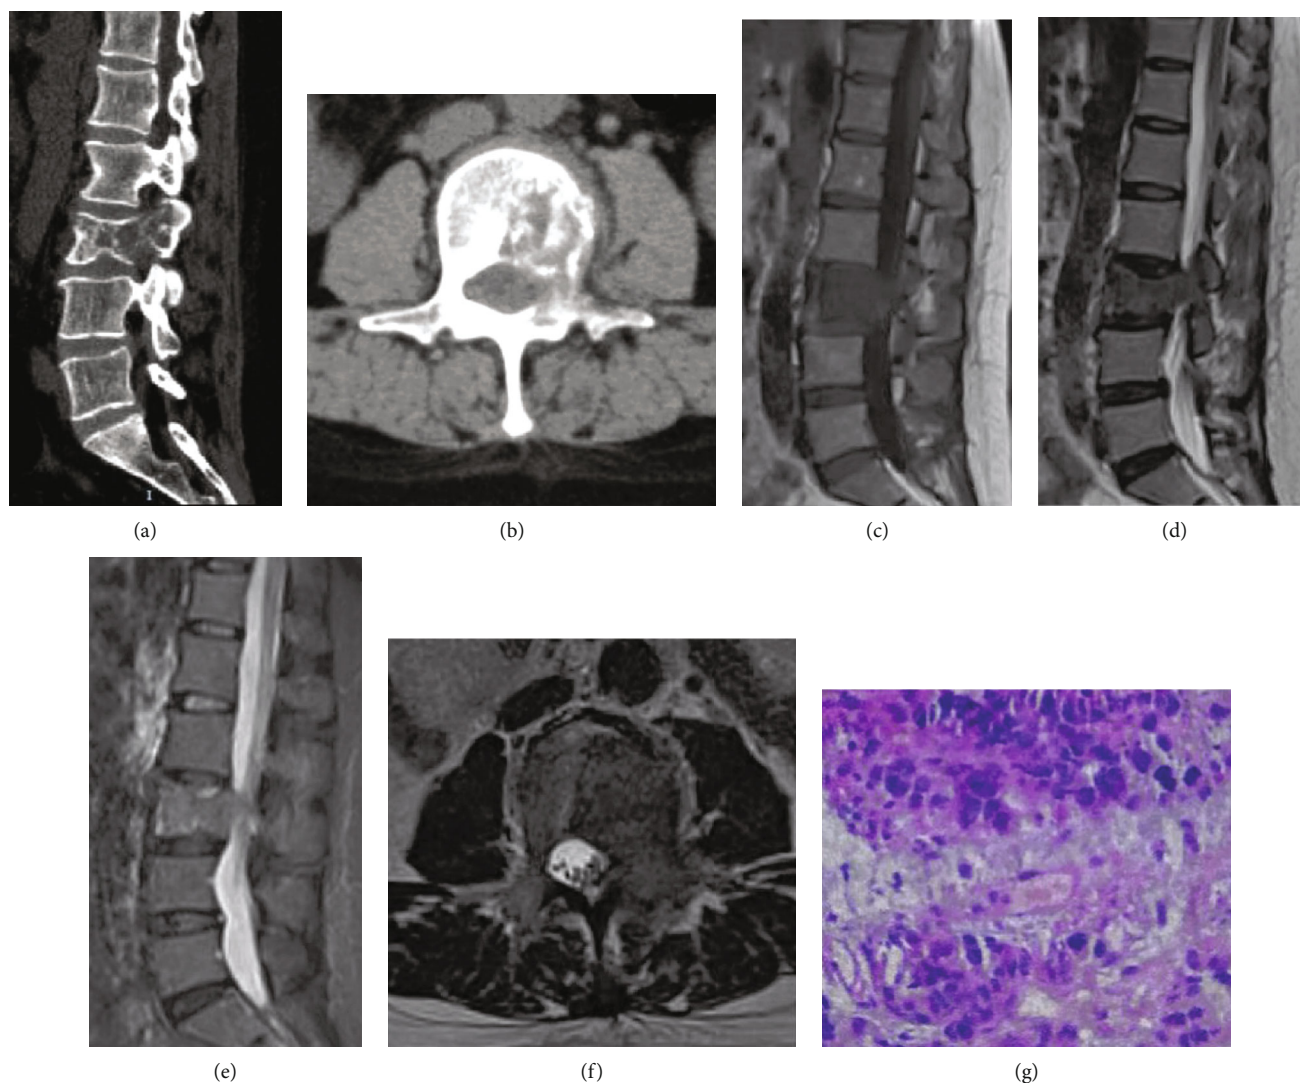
A 42-year-old female suffered from back pain for 6 months and double lower limbs weakness for 10 days with a breast cancer history. (a, b) Lumbar CT showed L3 vertebral body and attachment bone destruction, no subligamentous spread of abscess, no obvious narrow intervertebral space, and sequestra formation. (c–f) Lumbar MRI indicated that L3 vertebral body and attachment bone destruction, but intervertebral disc was normal. (g) The score was 10 points and the preoperative diagnosis was spinal metastasis which was consistent with the postoperative pathological diagnosis (metastatic adenocarcinoma).
